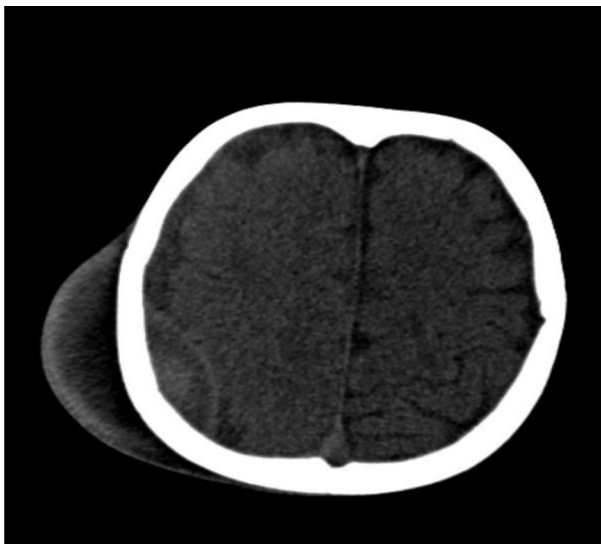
Axial computed tomography scan showing right parietal epidural hematoma containing mixed-type densities.
